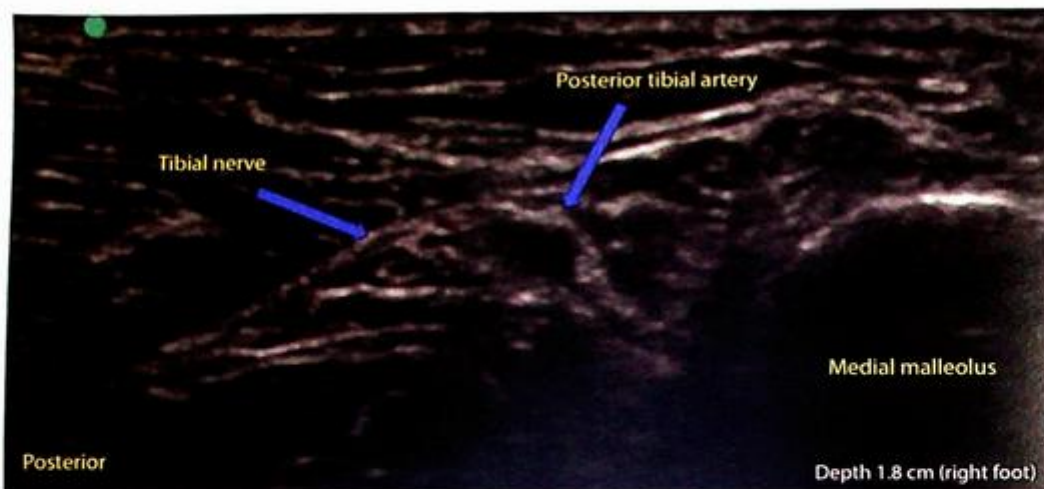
Ultrasound still of the tibial nerve and surrounding anatomy.
